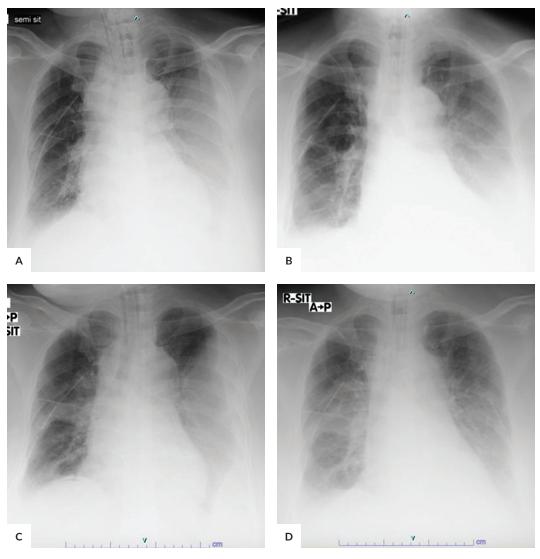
Serial chest x-ray done to show pleural effusion at left hemithorax. (A) Chest x-ray done during 10th hospital day with noted increasing left pleural effusion. (B) On 11th hospital day, repeat chest x-ray done after thoracentesis at left hemithorax. (C) On 14th Hospital day, noted progression of pleural effusion at left hemithorax. (D) On 15th hospital day, chest tube insertion done at left hemithorax and drained 600cc seropurulent fluid.
